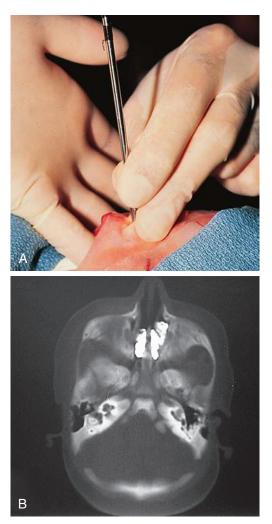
Choanal atresia. A, This infant manifested severe respiratory distress at delivery, with paradoxic cyanosis. Attempts to pass a urethral sound suggested bony obstruction of the choanae bilaterally. B, A CT scan done after instillation of radiopaque dye reveals pooling of the dye within the nose anterior to the choanae, confirming complete obstruction.
